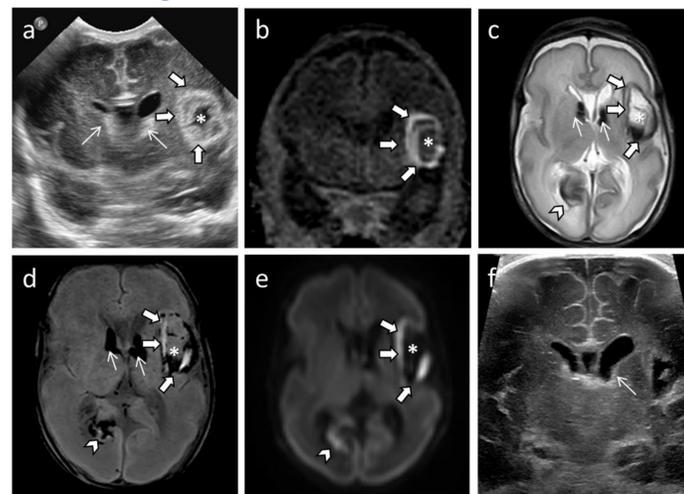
Baby girl born at 27 weeks in the setting of maternal preeclampsia complicated by SARS-COV-2 infection. Routine head ultrasound obtained at one month of life. Example of multifocal subpial hemorrhage.
